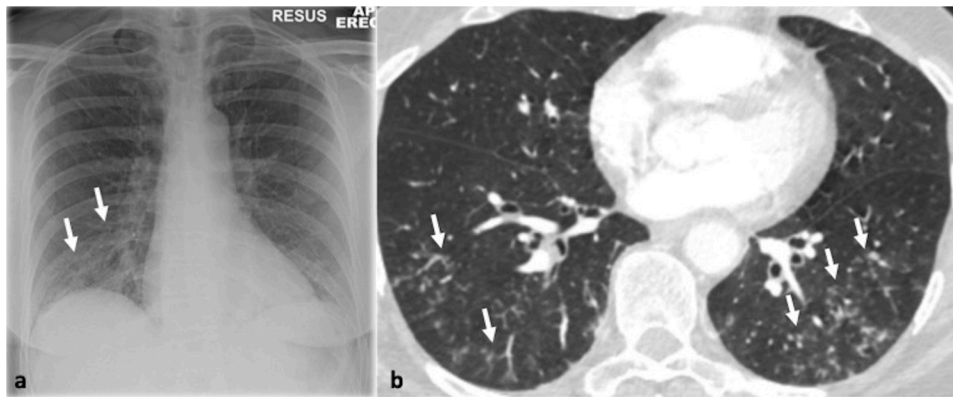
54-year-old woman with fever and cough. Parainfluenza was the only pathogen recovered from respiratory secretions. 3a. Chest x-ray shows reticulonodular opacities in the right lower zone (arrows). 3b. Transverse thin section CT scan confirms the presence of multiple micronodules and branching opacities (arrows).
